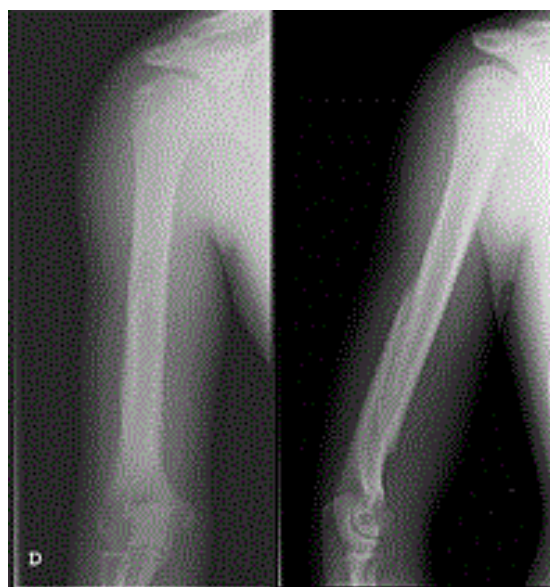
Radiography performed after four months of injury, during follow-up, showing fracture healing.
